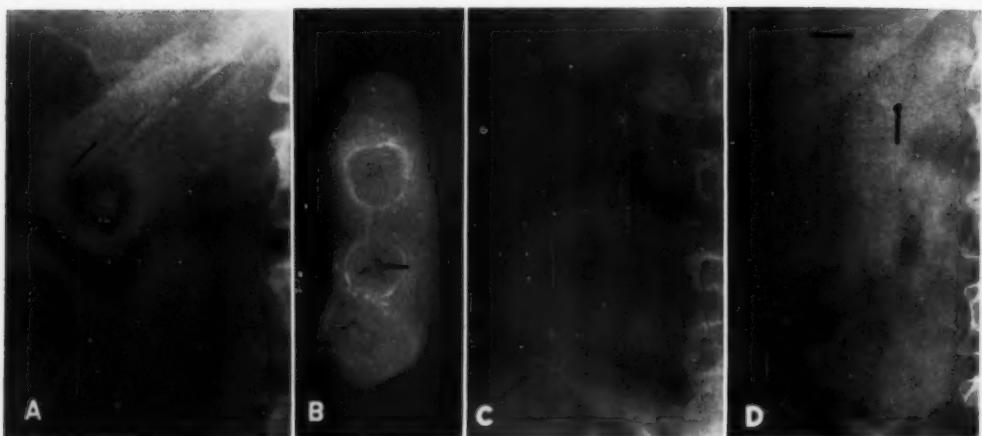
Gallstones and enlarged gallbladder diagnosed on preliminary films. A and B. Stellate radiolucencies (arrows) indicate gas-containing stones in gallbladder, thus enabling diagnosis on plain films. C. Widely separated laminated stones in a huge gallbladder (arrows). Lack of movement of superior stone indicates impaction in neck. D. Greatly enlarged gallbladder outlined at inferior margin by gas in colon. Large, poorly opaque stones are widely separated except those impacted in neck (arrows).
